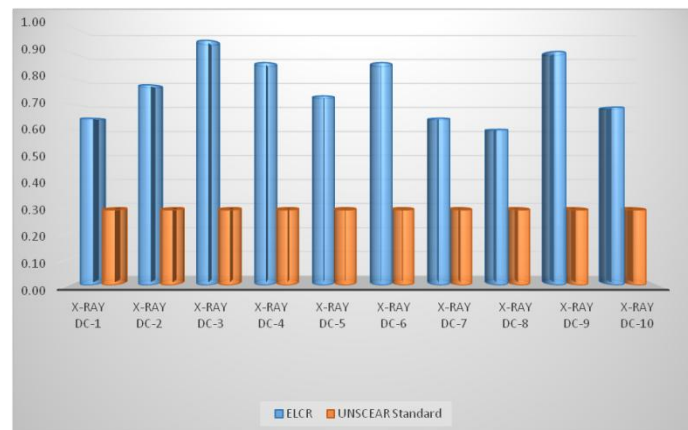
Excess Lifetime Cancer Risk of the sampled X-ray diagnostic centers with UNSCEAR, 2008
